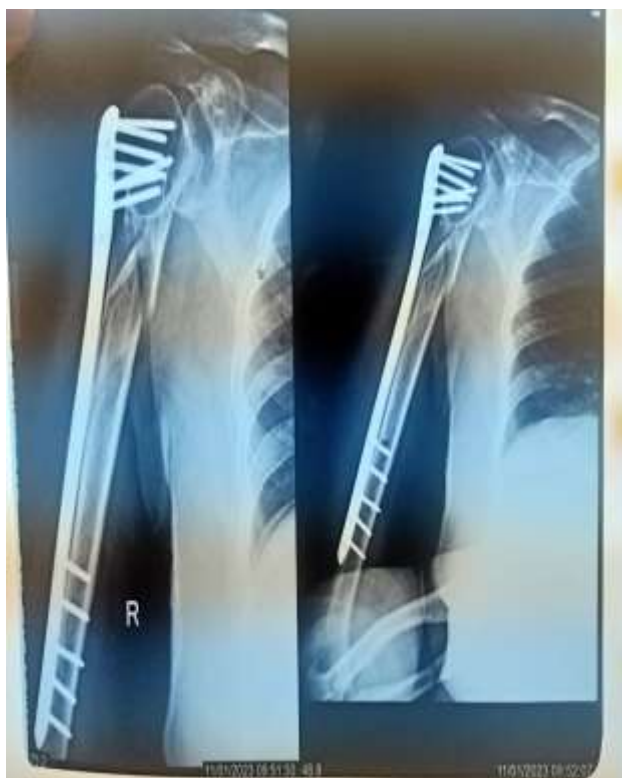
three months post operative X-Ray
